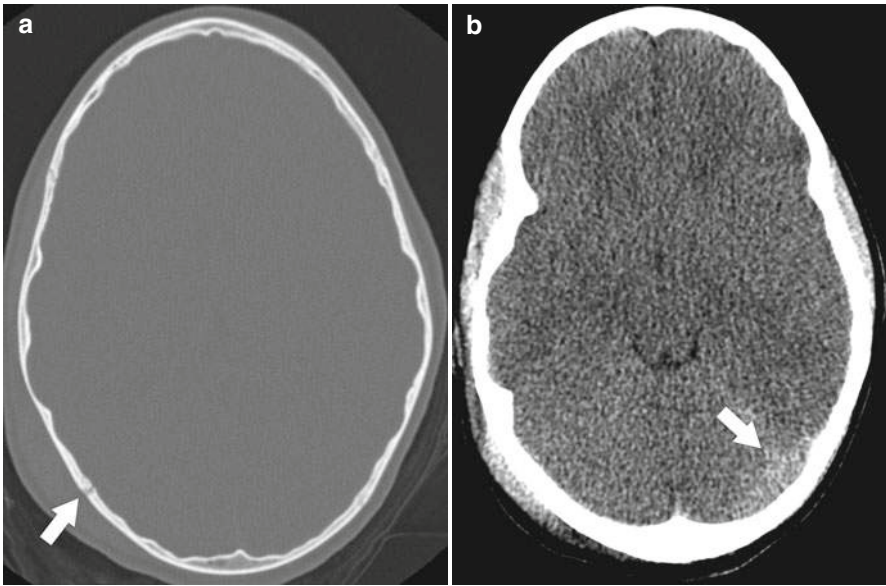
Intracranial hemorrhage with skull fracture. Head CT bone window (a) shows a right parietal skull fracture (*arrow*). Soft tissue window (b) shows left subdural blood (*arrow*)
